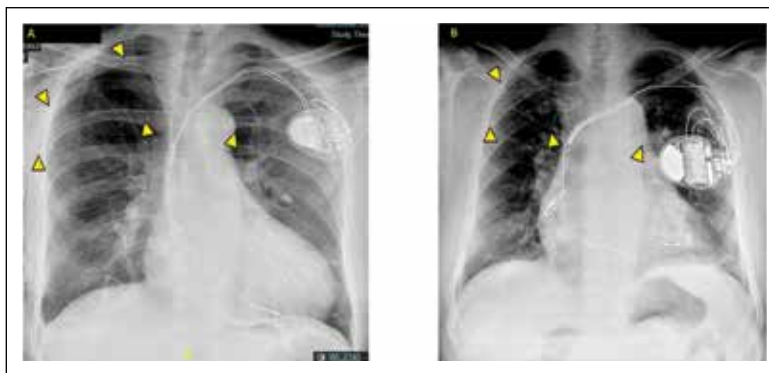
Two patients' Frontal radiographs show tunnelled LV lead from the right side to the left infraclavicular site. Patient A is a case of CHB who underwent a dual chamber pacemaker in past and now presented with severe LV dysfunction as the left subclavian venogram showed a completely occluded vein, a right-sided quadripolar LV lead (arrowheads) was inserted and then tunneled sub-sternally towards the left infraclavicular subcutaneous pocket and connected to a Medtronic CRT-P pulse generator. Patient B is a case of Anterior wall STEMI with CHB and VT and underwent dual chamber AICD and currently has worsening LV dysfunction and heart failure. As the left subclavian venogram showed a completely occluded vein, a quadripolar LV lead (arrowhead) was implanted from the right subclavian access, tunneled to the left infraclavicular fossa, and upgraded to the CRT-D system.
